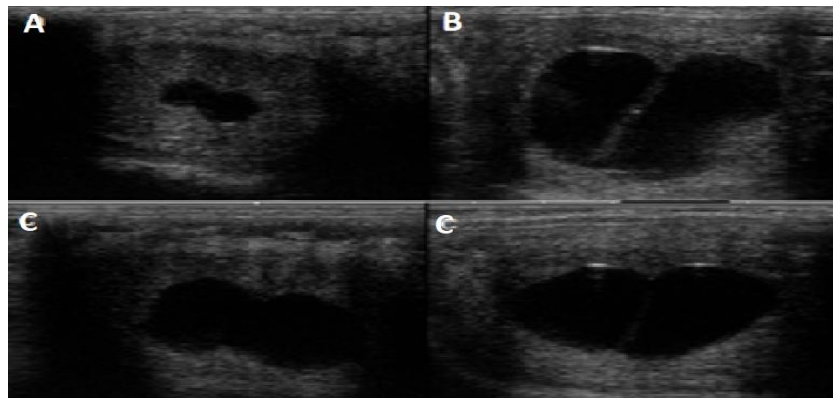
Ultrasound images of embryonic vesicle combined with a uterine cyst in different mares.
